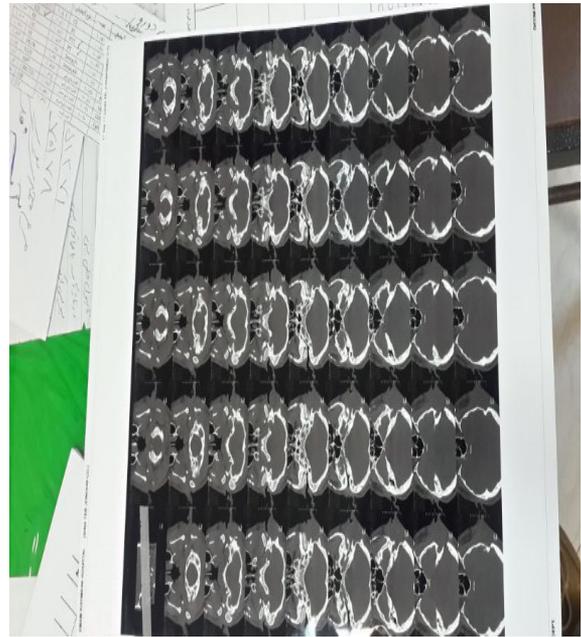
Axial Temporal Bone Computed Tomography scan of Patients revealed structural changes of median ear include widening of aditus, and erosion of scutum; erosion of malleus and tegmen. All the evidence of the image was in favor of the Cholesteatoma.
